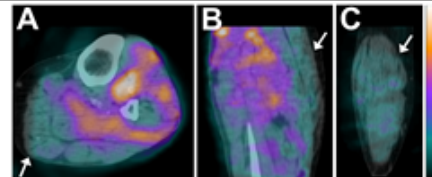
SPECT/CT perfusion imaging of the calf under resting conditions. A) Axial, B) sagittal, and C) coronal views of fused SPECT/CT images reveal a regional perfusion deficit in the gastrocnemius muscle (denoted by white arrows).
